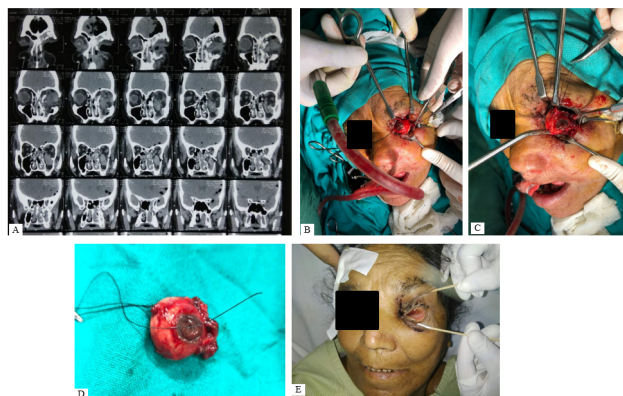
A): CT scan shows displacement of left hypotonic eyeball in maxillary sinus; B, C, D): Intraoperative procedure images of globe reduction in orbital cavity and enucleated globe; E): Post op image of the patient
